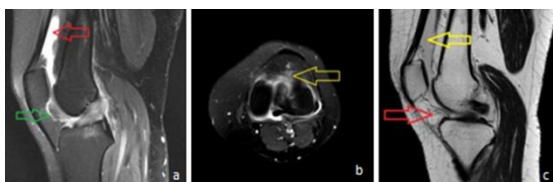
MRI left knee of 15-years old male with history of trauma.(a)sagittal section proton density with fat saturation shows superior recess of Hoffa's pad (red arrow) .(b) T1W sagittal section shows well delineated hyperintense Hoffa's fat pad (yellow star).
